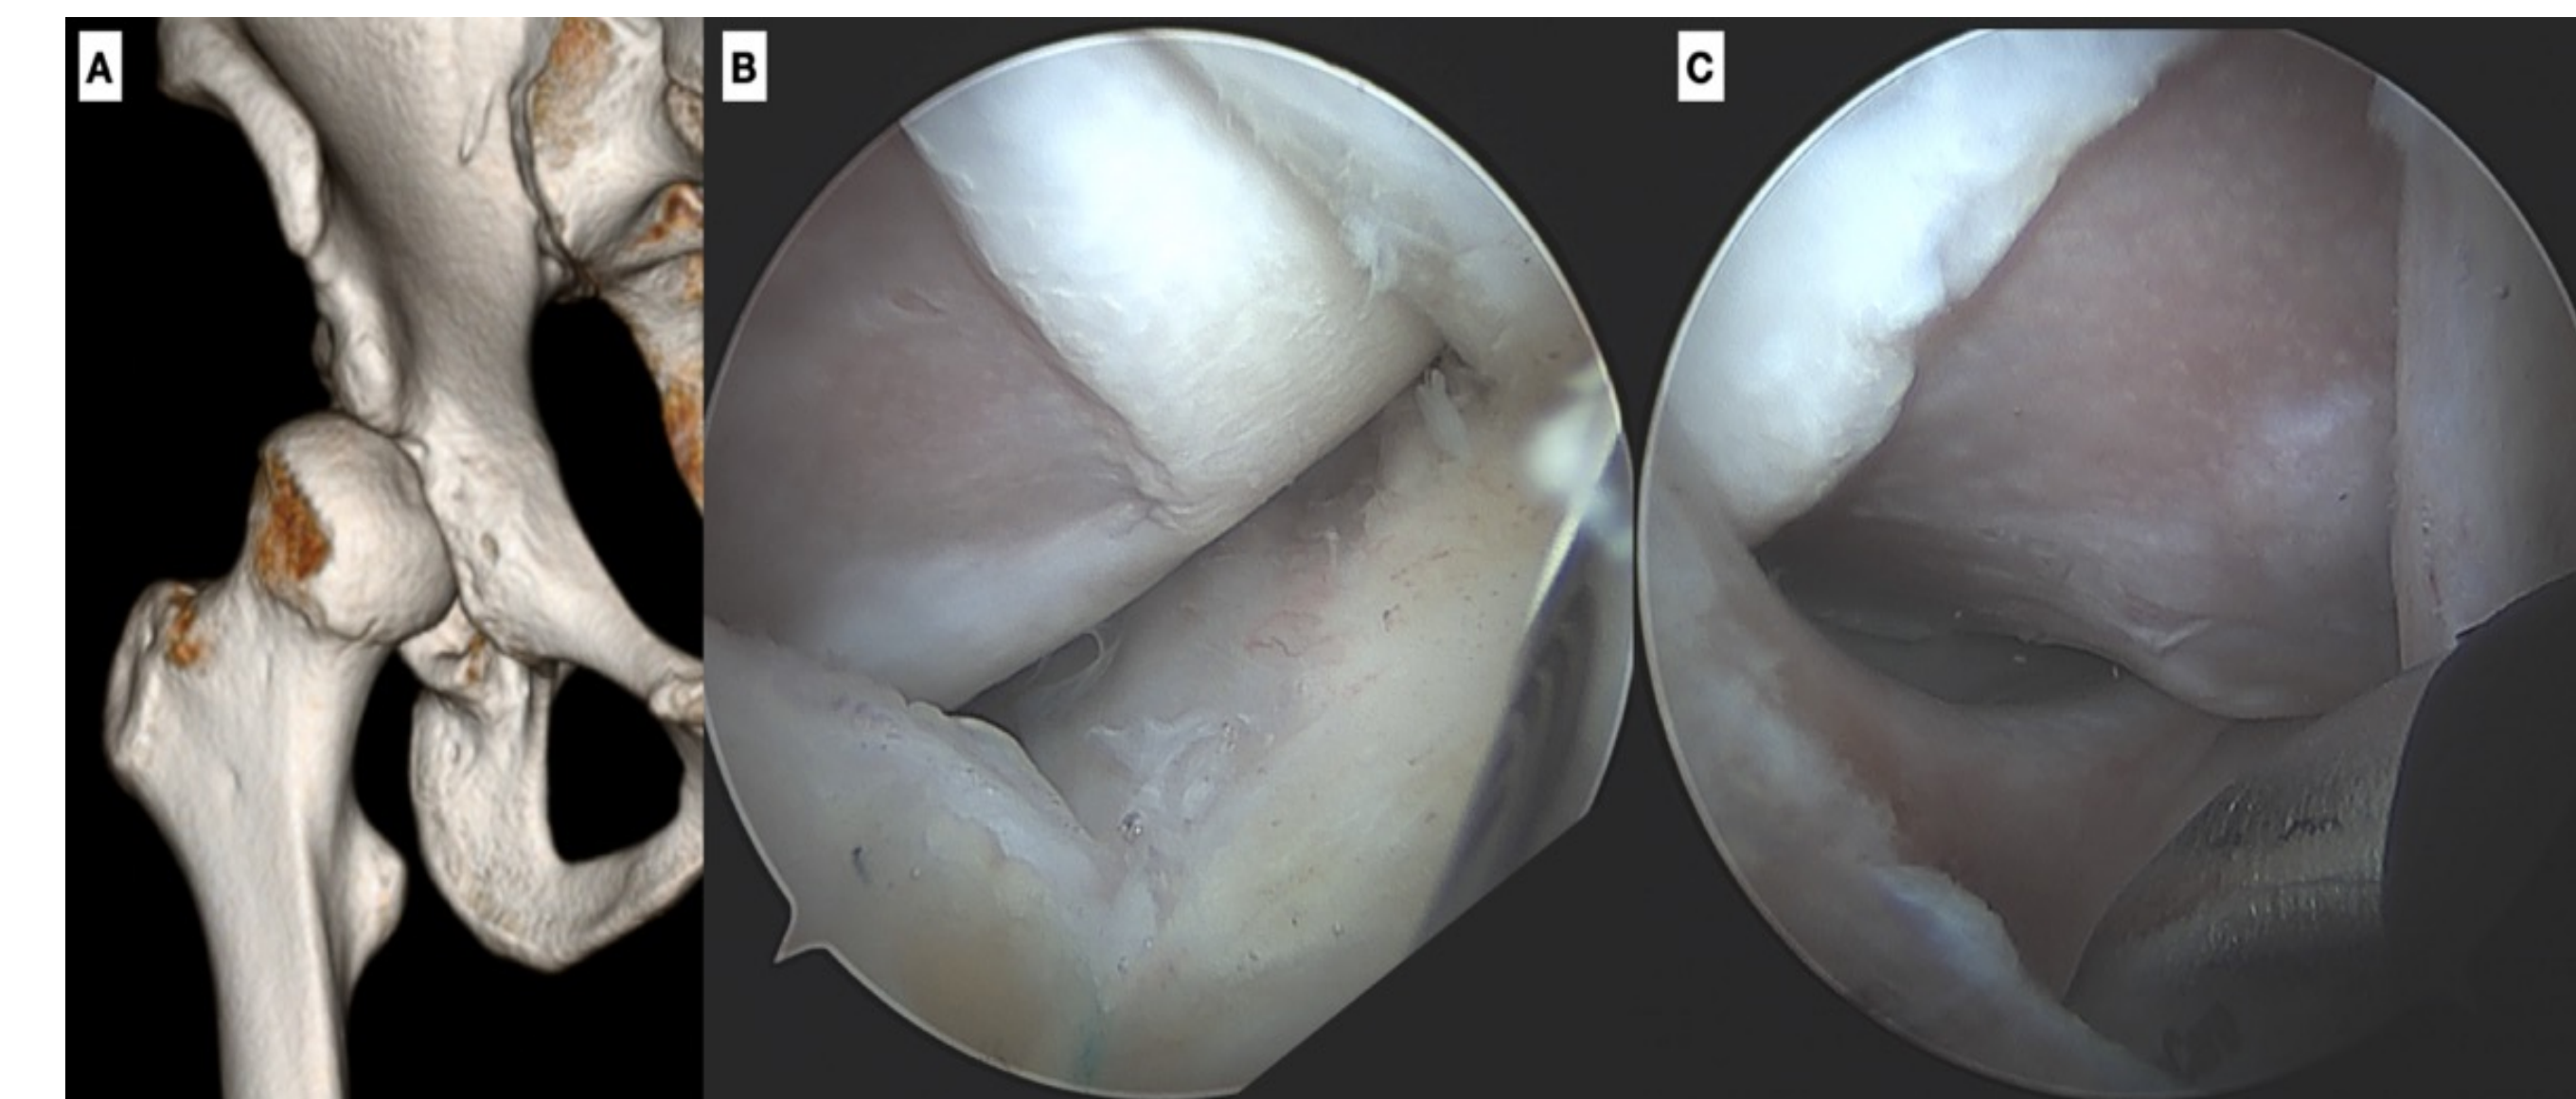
Images showing a right hip WSW sign in a patient with no prior surgical history. A) 3D computed tomography (CT) reconstruction of the right hip demonstrating the extent and location of the WSW sign defect. B) Arthroscopic image corresponding with the same lesion seen on 3D CT. C) Arthroscopic image in extension, off traction, demonstrating the compromise of the labral suction seal with gapping between the labrum and femoral head.
